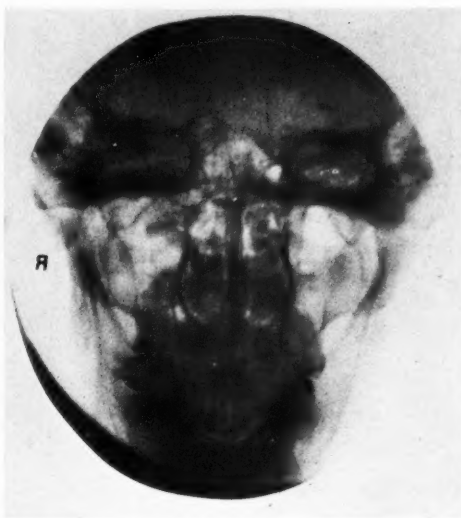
Radiograph, reported by Dr. Granger as a chronic sphenoiditis and posterior ethmoiditis, with hyperplastic changes on the right side.
